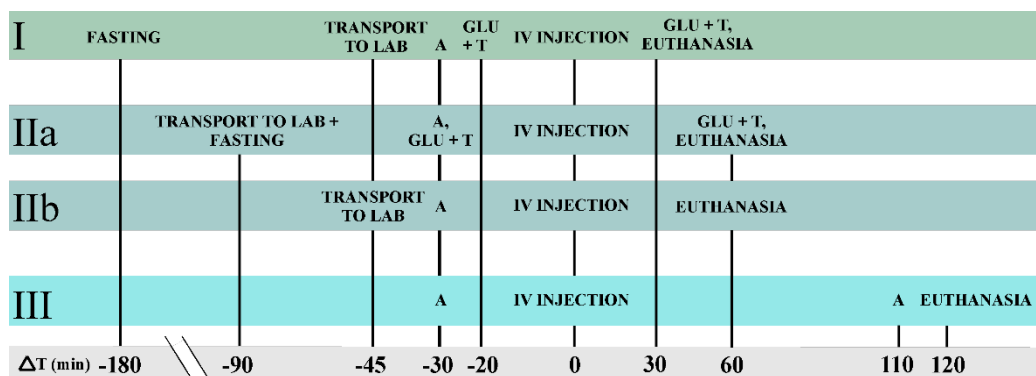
Ex vivo* autoradiography work flow for studies I-III in accordance to the tracer injection time at 0. ^{18}F -FDG was used in studies I and IIa, whereas ^{18}F -DPA-714 was used in IIb. For Study III, ^{18}F -FMPEP- d_2 was utilized for autoradiography. A, anesthesia; GLU, glucose; IV, intravenous; T, temperature.
